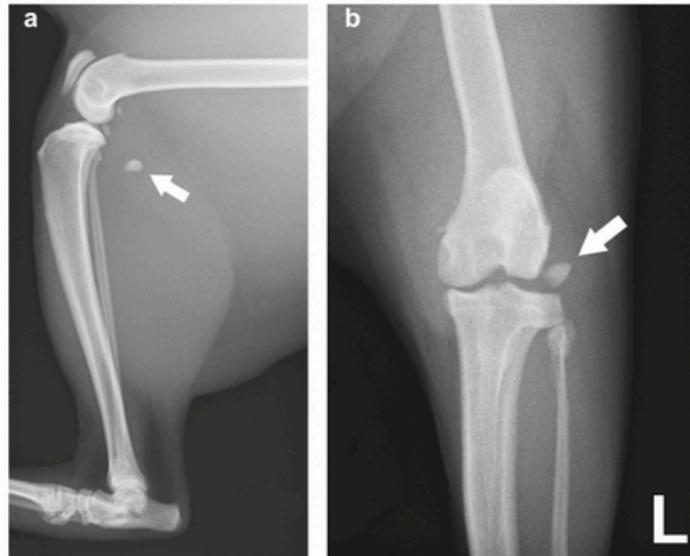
(a and b) Preoperative radiographs of the left stifle, with the hook in flexion, demonstrating a distal displacement of the lateral fabella (white arrow).
